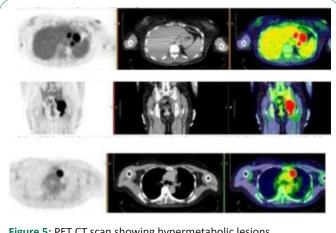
PET CT scan showing hypermetabolic lesions.
